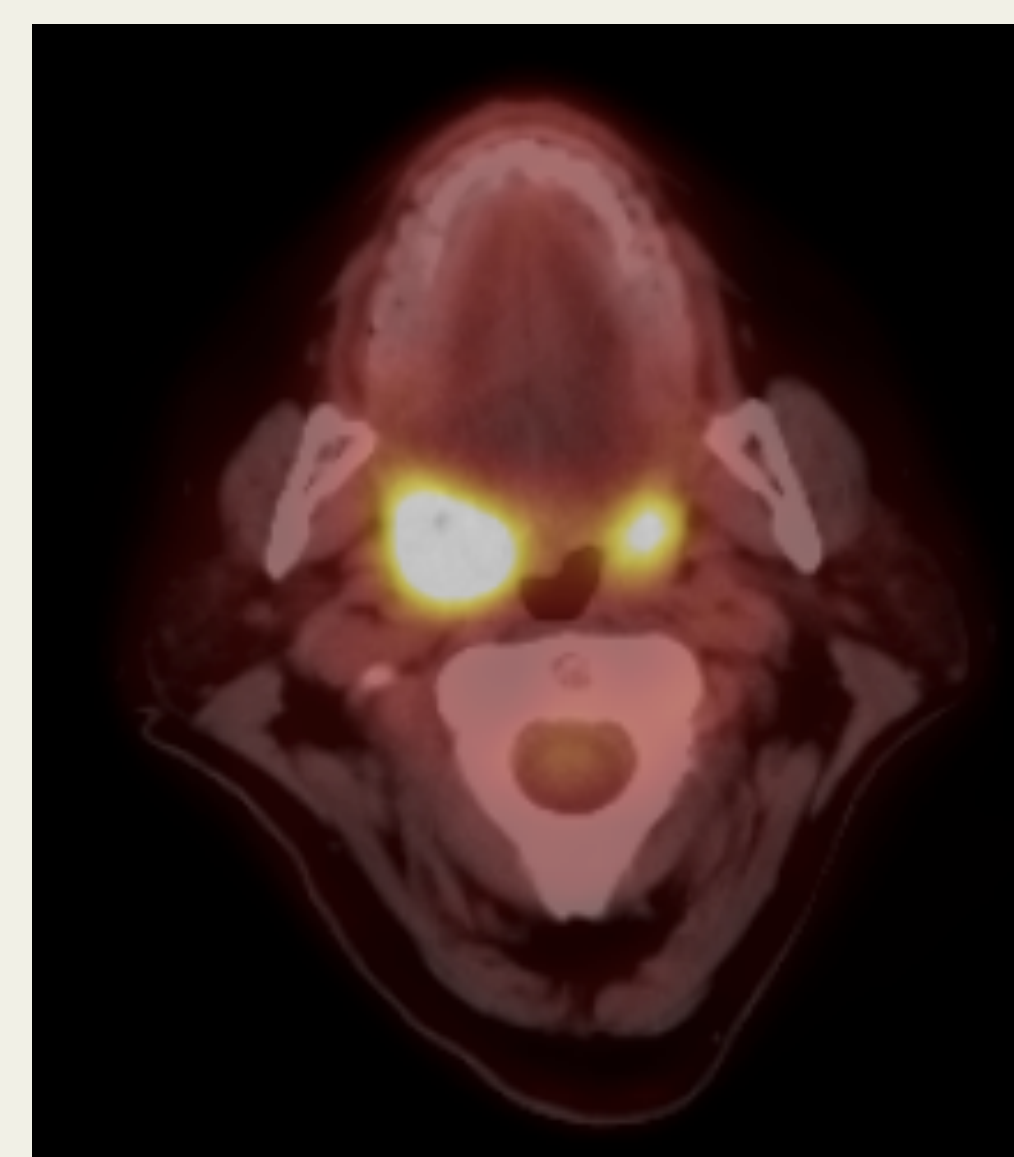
PET/CT showing hypermetabolic right tonsil (SUV 19) and Hypermetabolic left tonsil (SUV 9)
